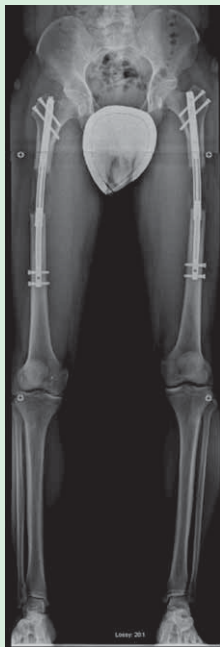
AP radiograph of bilateral femoral lengthening seen during an 8-cm cosmetic stature lengthening. This went on to heal uneventfully. The mild varus neutralizes the valgus deviation that is associated with lengthening along the anatomic axis. The concern is mostly regarding the risks of nail breakage. Strict weight-bearing precautions should accompany any bilateral lengthening and especially if bowing is seen.
